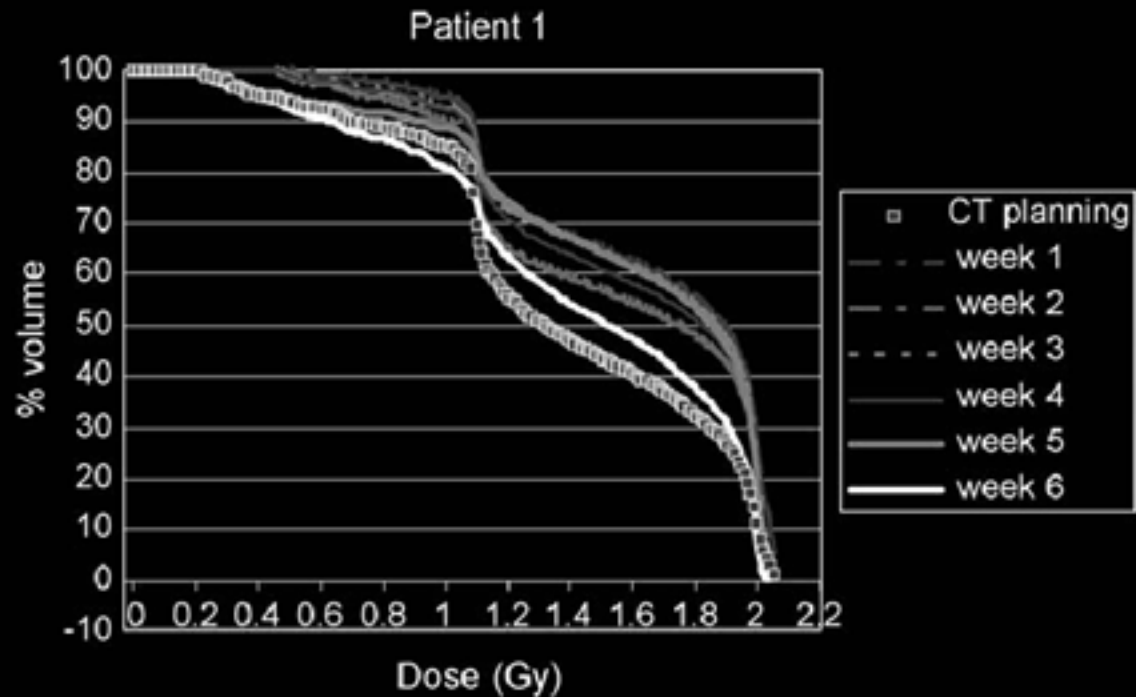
Rectum DVH trend: the DVH at planning scan (CT planning) and the DVHs during the treatment (week 1...week 6) are shown for a patient with a large systematic component of the difference between planning and therapy (Patient 1).
